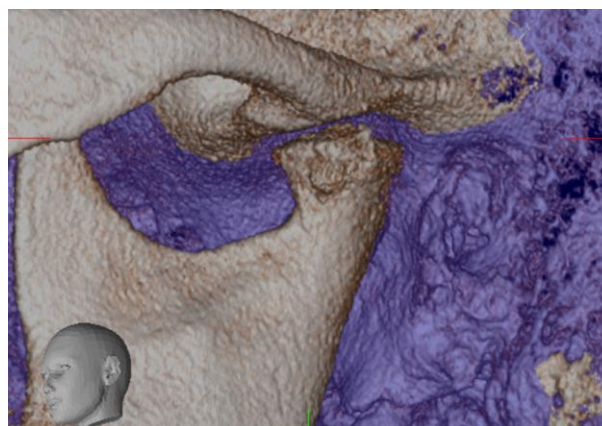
Cone beam computerized tomography has advantages in the diagnostics of osseous tissues including osteoarthritis
